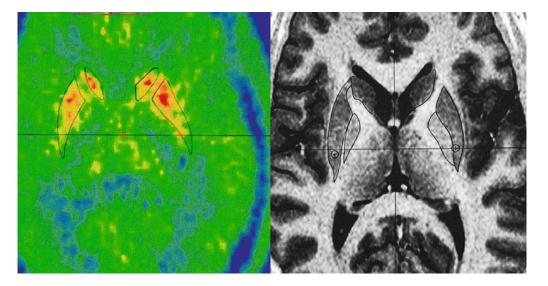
Stereotactic MRI-directed targeting of postero-dorsal putamen for catheter implantation. Baseline <sup>18</sup>F-dopa PET scan used for co-localization within the posterior putamen dopamine deficient areas
